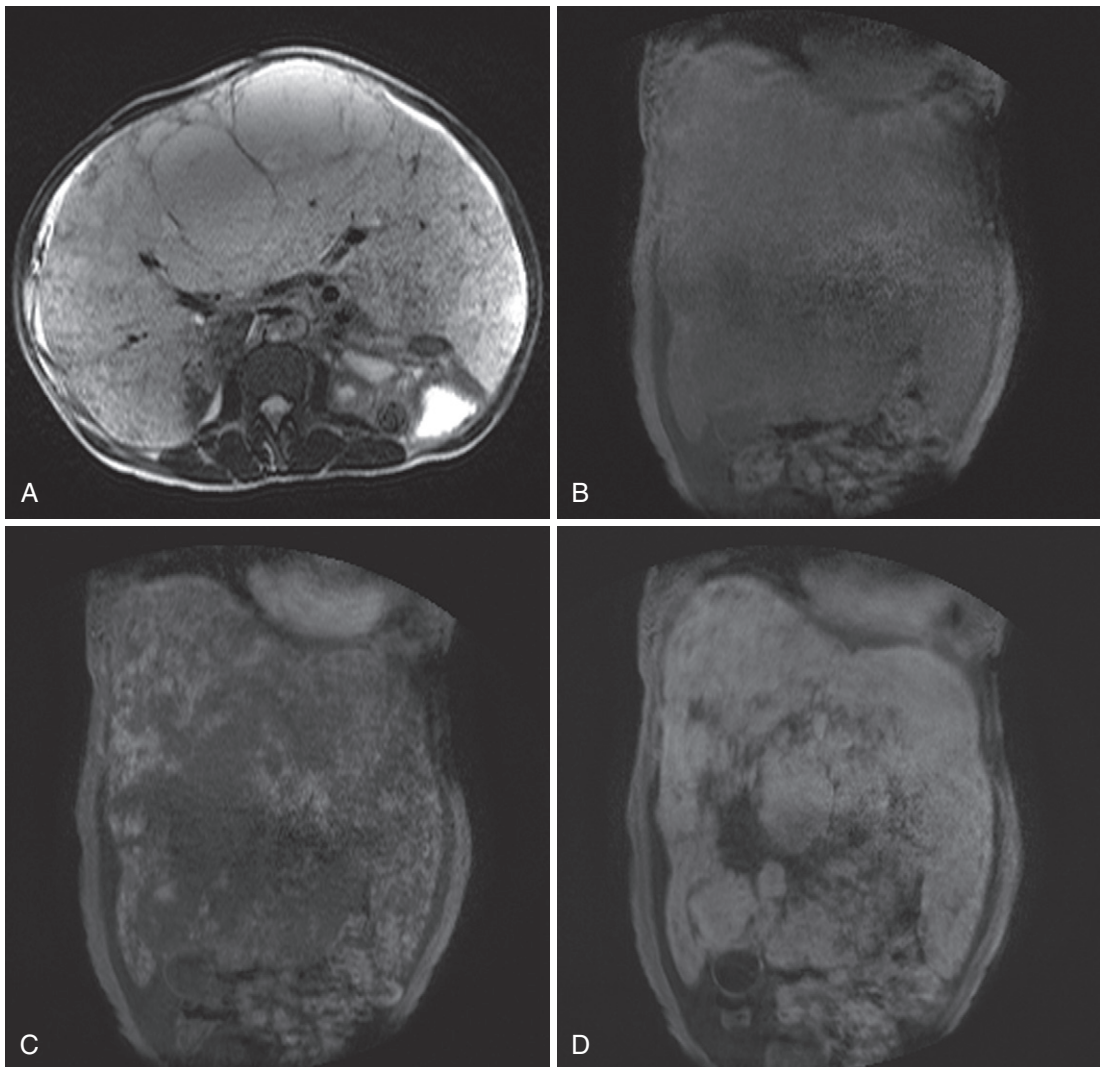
Hemangiomatosis. Replacement of the normal hepatic parenchyma by ill-defined, near-fluid hyperintensity on the axial T2-weighted image (A) with gross hepatomegaly evident on the precontrast T1-weighted image (B). Following the administration of intravenous gadolinium, multifocal nodular enhancement on the arterial phase image (C) progresses to near-complete enhancement on the delayed image (D), reminiscent of a hemangioma.
